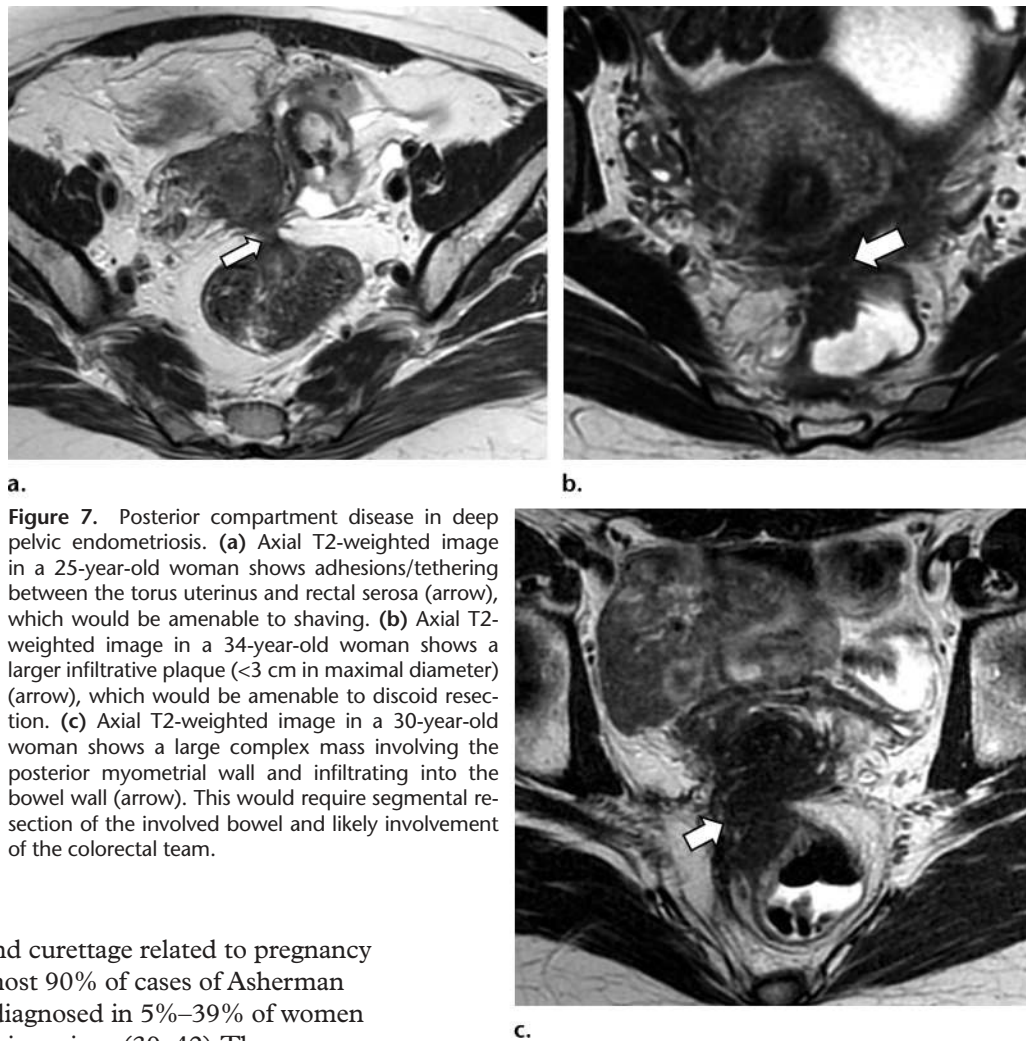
Posterior compartment disease in deep pelvic endometriosis. (a) Axial T2-weighted image in a 25-year-old woman shows adhesions/tethering between the torus uterinus and rectal serosa (arrow), which would be amenable to shaving. (b) Axial T2-weighted image in a 34-year-old woman shows a larger infiltrative plaque (<3 cm in maximal diameter) (arrow), which would be amenable to discoid resection. (c) Axial T2-weighted image in a 30-year-old woman shows a large complex mass involving the posterior myometrial wall and infiltrating into the bowel wall (arrow). This would require segmental resection of the involved bowel and likely involvement of the colorectal team.
